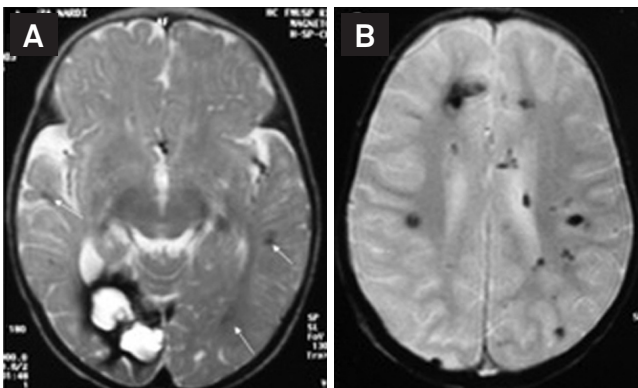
Axial T2-weighted magnetic resonance imaging (A) revealed a right occipital lesion with a hypointense halo around it, and other lesions can also be seen (arrows). The gradient-echo sequence (B) confirmed multiple cavernous malformations (Patient 12).
